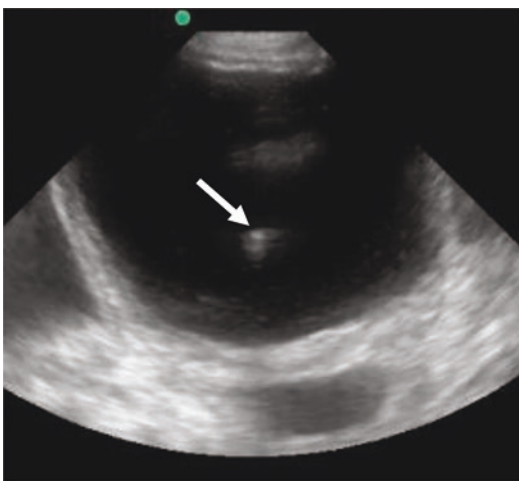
Ultrasound of the needle tip (arrow) within the bladder during suprapubic aspiration
